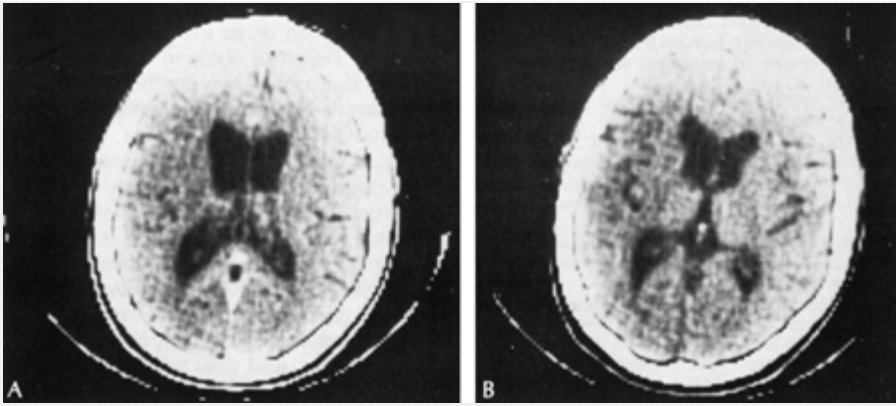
A and B, CT scans at two axial levels show ventricular enlargement with atrophy of the caudate nucleus, particularly the head of the caudate. (Reprinted with permission from Rowland LP, ed. *Merritt's Text book of Neurology*. 9th ed. Baltimore: Lippincott Williams & Wilkins; 1995:698.)
